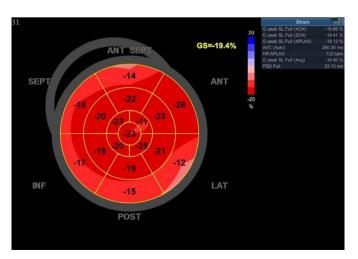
Echocardiography at admission, GS -19.4%
